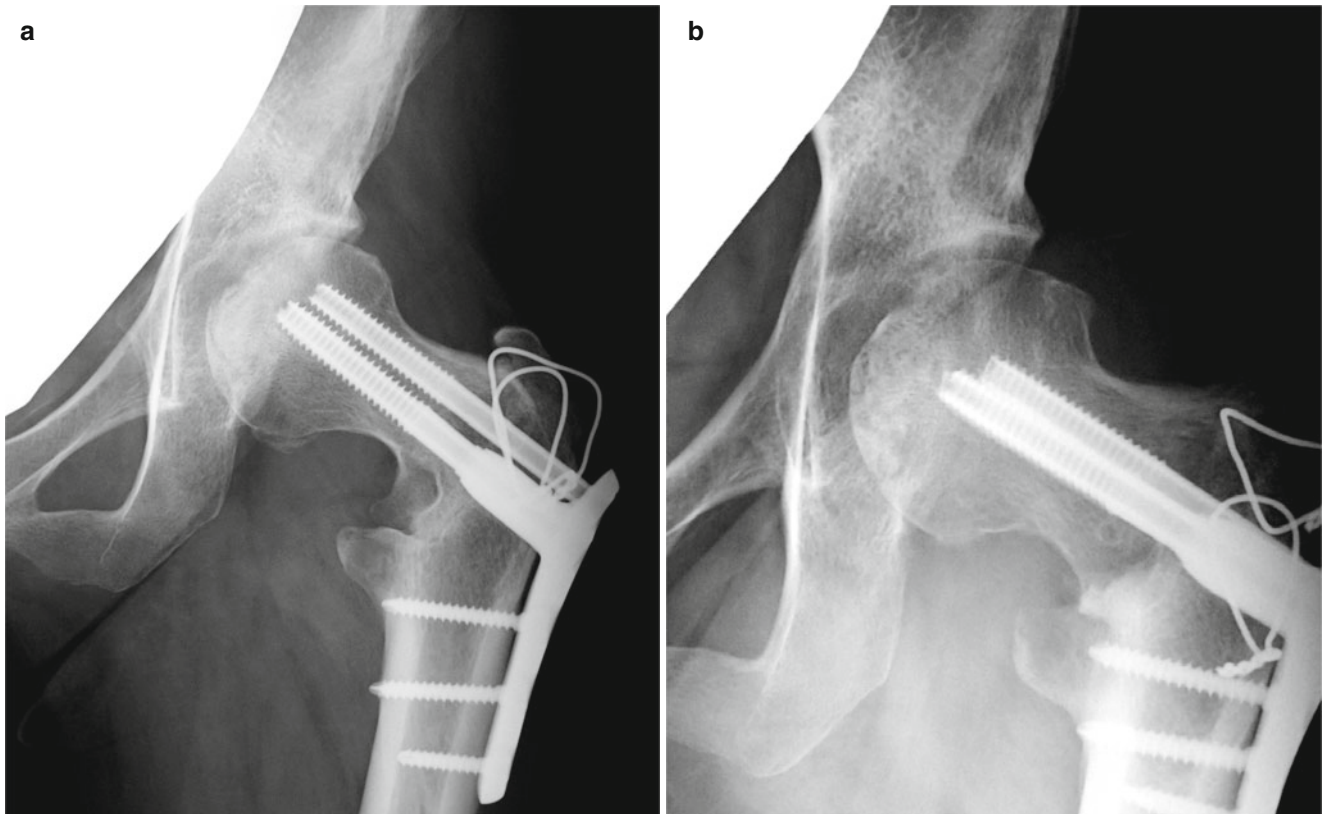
Following radiographs of Figs. 46.2 and 46.3. (a). 120° posterior rotation was performed. AP radiograph taken 6 months after operation showed that collapsed lesion with subchondral fracture was moved to the medial portion. Note the spherical viable area was placed
